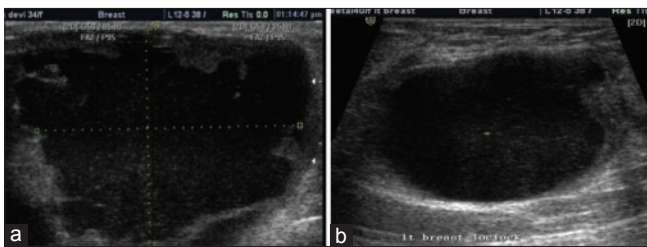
11b): Abscesses. Breast USG (Fig.11a) in a 34-years old lactating woman with high-grade fever, present with a painful breast lump, skin erythema and edema, shows a large heterogeneously anechoic, predominantly cystic lesion with mobile internal debris and adjacent inflammatory breast tissue with increased vascularity on Doppler. Another 40 years old, non- lactating female with similar complaints and USG findings (Fig.11b)
